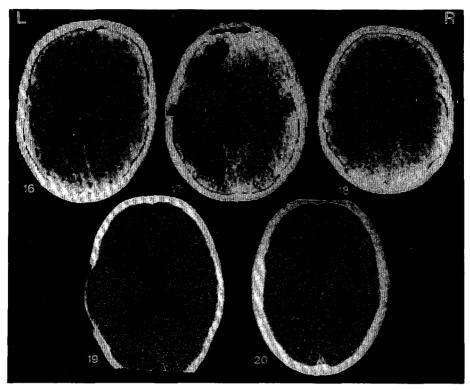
CT scans of 5 patients with infectious diseases.
